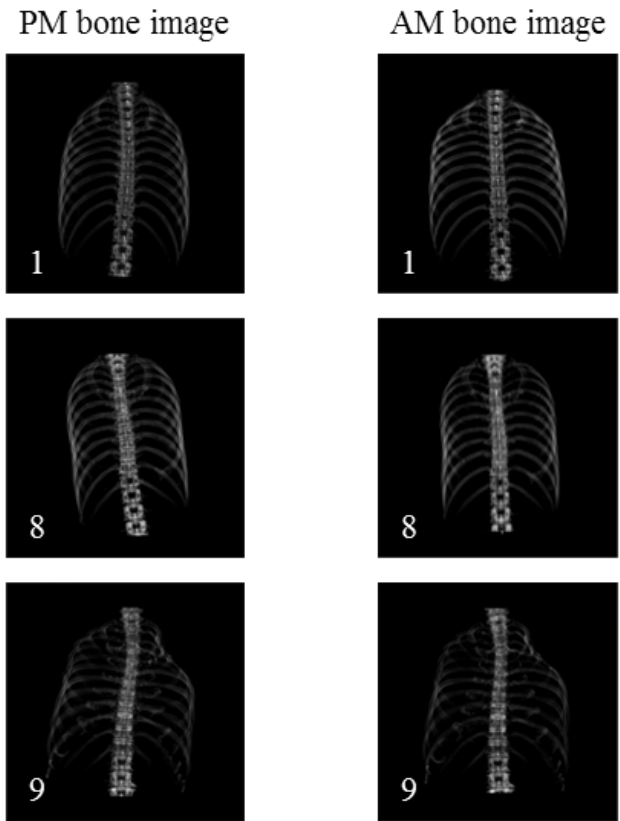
Examples of PM and AM 2D bone images (cases 1, 8, and 9) obtained from chest CT images.
